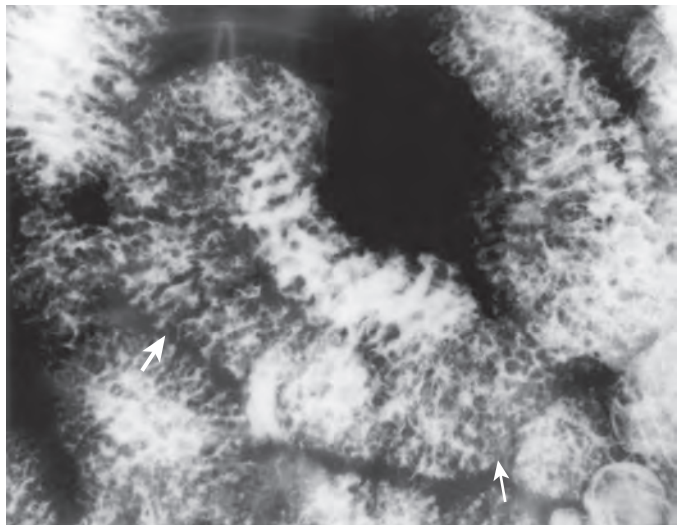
Lymphoma as a cause of diffuse nodular fold thickening. This spot radiograph from a small bowel follow-through shows moderately thickened, nodular small bowel folds (thick arrow). Tiny nodules reflect villous enlargement (thin arrow). This radiographic appearance is unusual for non-Hodgkin's lymphoma involving the small bowel but can be seen in T-cell lymphoma complicating celiac disease, Mediterranean lymphoma associated with immunoproliferative small intestinal disease, and lymphoma in patients with AIDS. (Courtesy K. Cho, MD.)
